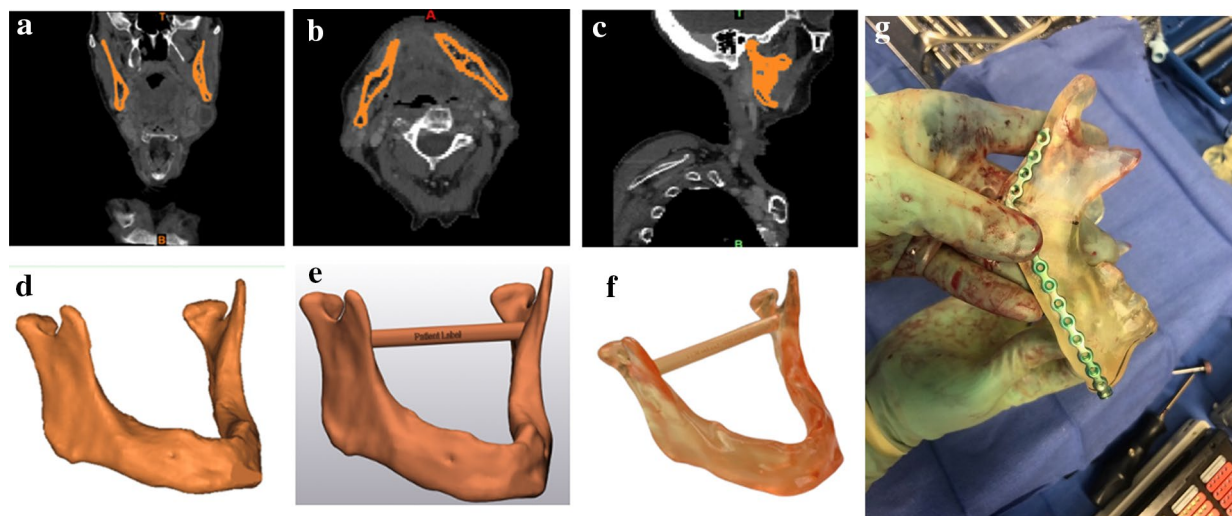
(a–c) Computed Tomography (CT) scan imported and isolated using Materialize 3-matic; (d) Cropped 3-D mandible model in Materialize 3-matic; (e) Final mandible in PreForm prior to printing; (f) Printed final mandible with post-processing complete; (g) Autoclaved sterilized mandible model being used intraoperatively for reconstructive surgery.
